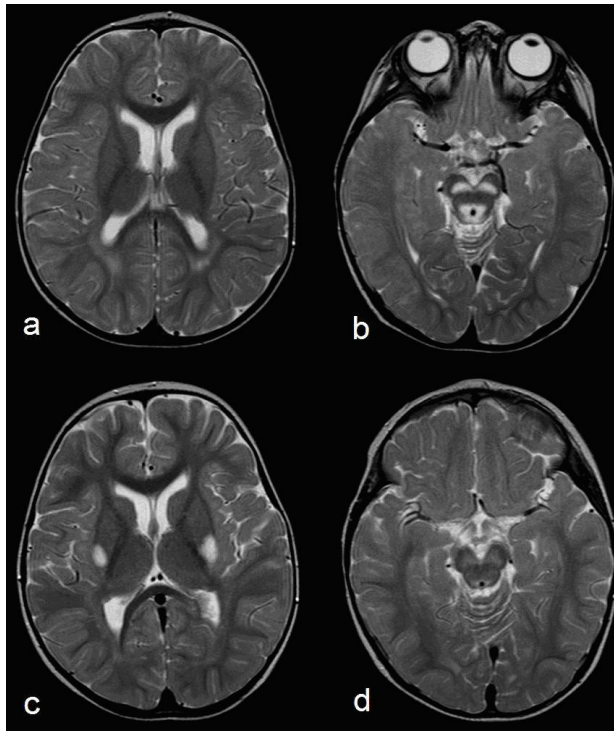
Patient with Leigh syndrome caused by the G13513A mutation in ND5 of mtDNA. An MRI with axial T2-weighted images at 16 months of age showed unaffected basal ganglia (a), bilateral symmetrical hyperintense lesions in the substantia nigra and periaqueductal gray matter (b). Follow-up MRI eight months later showed new bilateral symmetrical lesions in the posterior putamen (c), with partial regression of the previous lesions (d).
